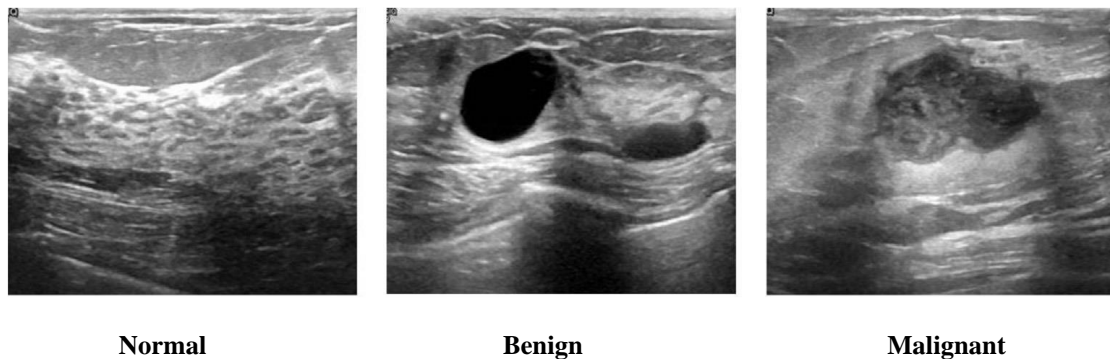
Sample Images from Breast Ultrasound Dataset [21]
